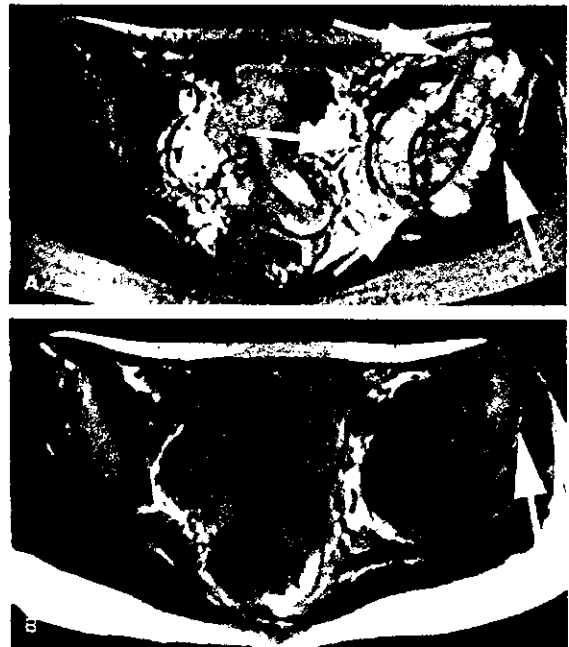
Adult neuroblastoma in 30-year-old woman with pain and fever. A: Axial T2-weighted MR image (4,500/112) shows poorly marginated tumor (arrows) with predominantly hyper-signal intensity relative to skeletal muscle in pelvic wall. B: Axial contrast-enhanced T1-weighted MR image (550/12) shows heterogeneous enhancement (arrow) and diffuse involvement of the left iliac bone.
